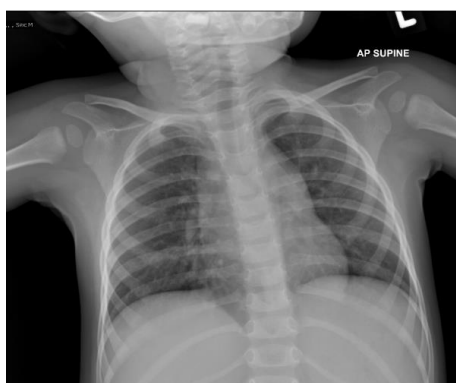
Chest x-ray of MY taken at diagnosis.
